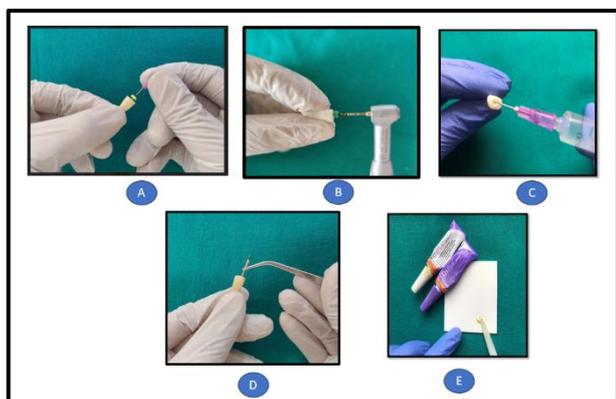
Preoperative radiographs (RVG) were taken and working length was taken with #10 K- FILE. Glide path was prepared using ProGlider which is of size 16 and 2% taper. (Dentsply Mailifer, Switzerland). Root canal cleaning and shaping was done using WaveOne Gold (Dentsply, Maillifer). The root canals were prepared till WaveOne Gold medium medium file i.e 35 size which is of 6% and irrigated with 5 mL of 5.25% sodium hypochlorite solution in between the use of each file.
